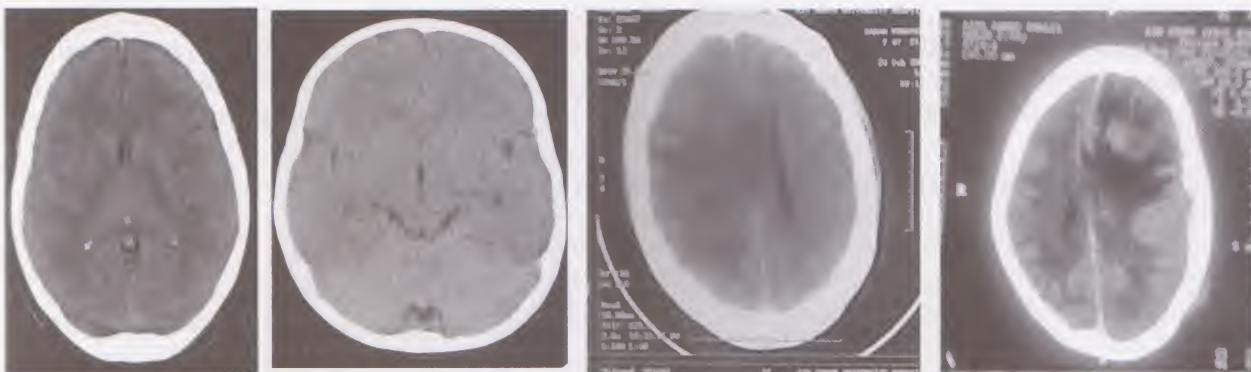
CT scan of the brain. The images from left to right show; the first image is normal with normal sized ventricles and grey white matter differentiation. The second image shows generalized brain edema with compressed ventricles and lost grey-white matter differentiation. The third and fourth images show peritumoral edema around a brain tumor with compressed ipsilateral ventricle and midline shift to the opposite side (i.e., mass effect)
